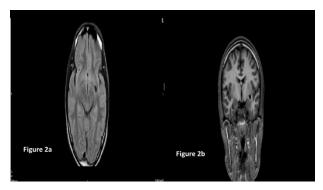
Coronal T2WI. Axial SWI. DWI/ADC Sagittal T1W1 preand post-contrast. Hypo intense fluid-attenuated inversion recovery (A). Focal oval cyst space with CSF signal measuring 17 mm in the external capsule in the left basal ganglia region like a lacune (macune) from a previous vascular insult (B).
